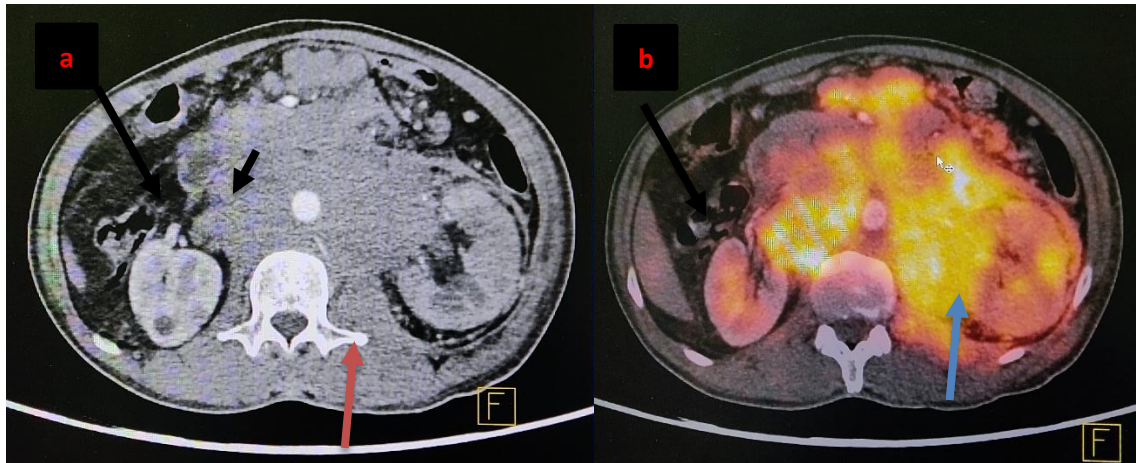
(a) Axial CT scan shows large conglomerated nodal mass in retroperitoneal and para-aortic region (black arrows) encasing the aorta (short black arrow), its branches and IVC; left kidney appeared bulky compared to right kidney (orange arrow) with multiple wedge shaped hypodense areas in the renal parenchyma however there was no definite infiltration by the nodal mass; nodal and renal involvement was positive considered positive by CT criteria; (b) Axial fused PET/CT image shows increased FDG activity in the nodal mass (black arrow) and in interpolar region of left kidney (blue arrow); nodal and renal involvement was considered positive by PET/CT criteria.
